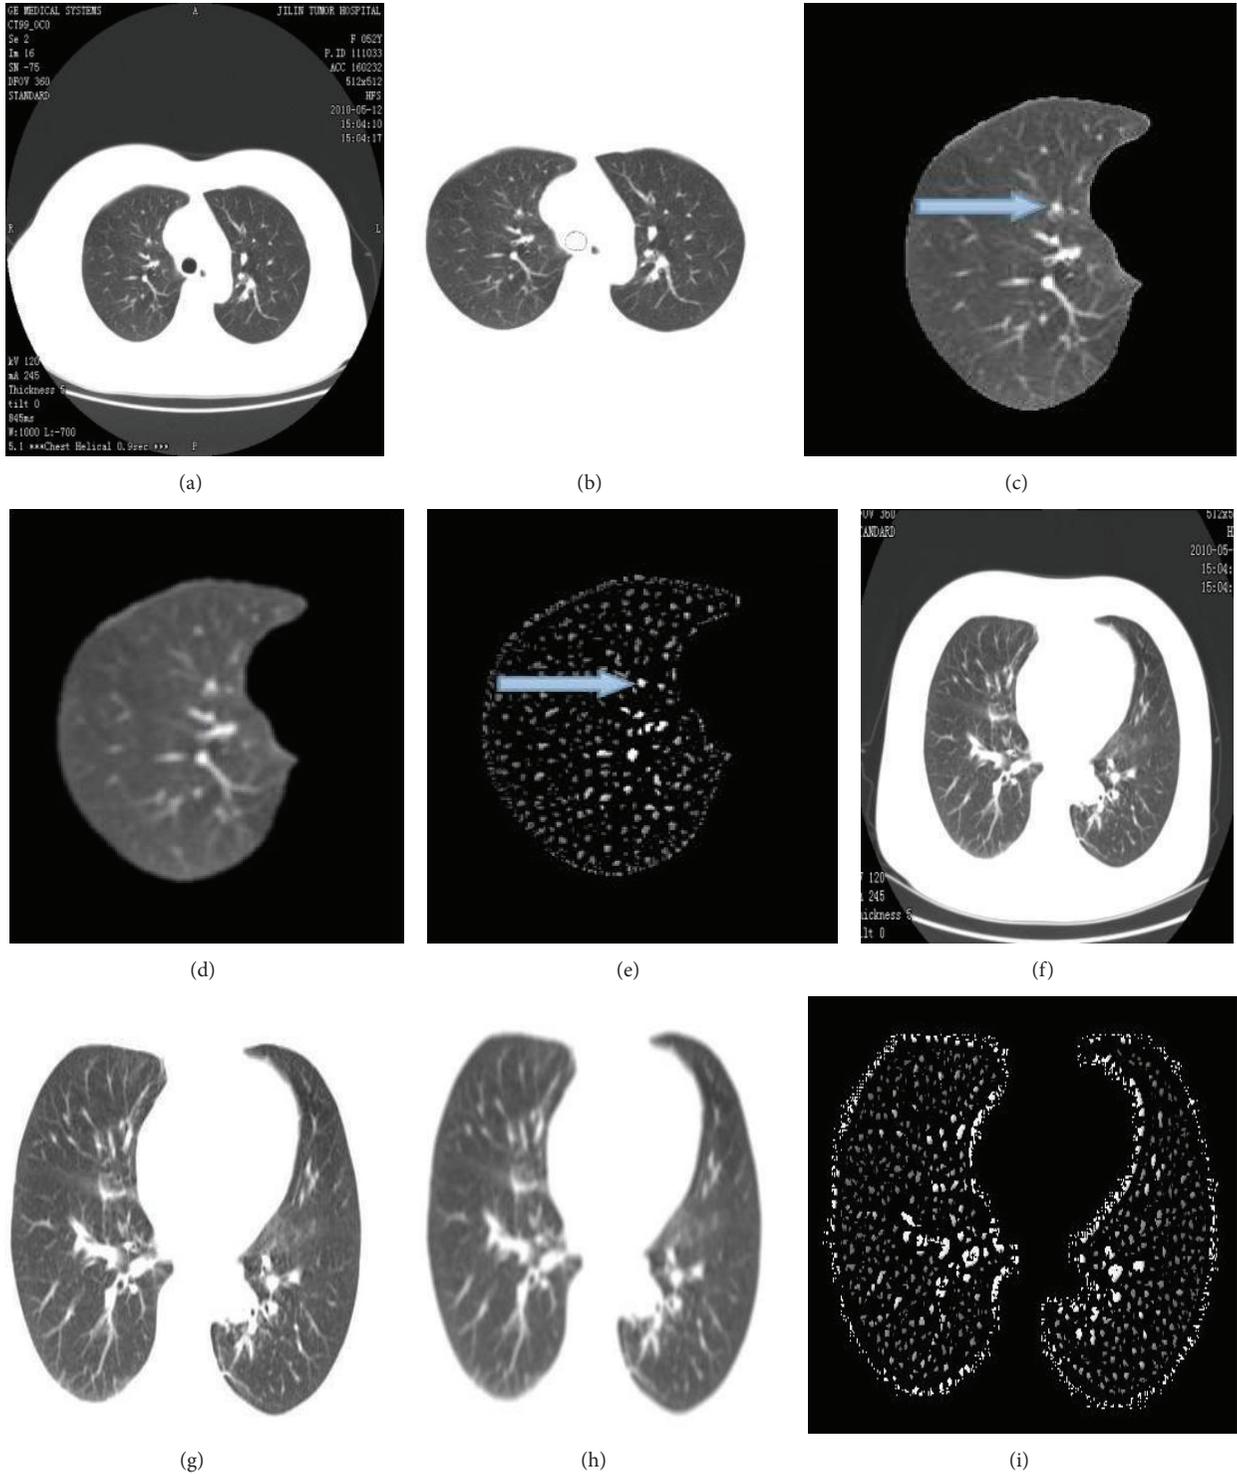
Detection of the solitary nodules in a 2D CT image enhanced by dot-Filter. (a) original lung image; (b) lung segment extraction; (c) the right lung segment; (d) lung CT image smoothed by Gauss function; (e) detection of the solitary nodules; (f) lung CT image without nodules; (g) pulmonary segment extracted; (h) smoothed by Gauss function; (i) enhanced by dot-filter.
